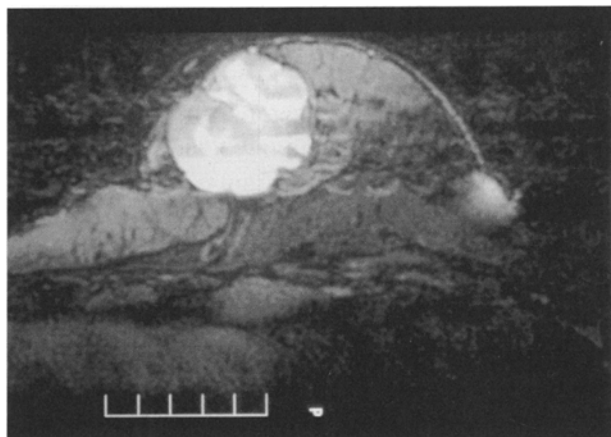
Magnetic resonance imaging scan revealed a multilocular cyst.
